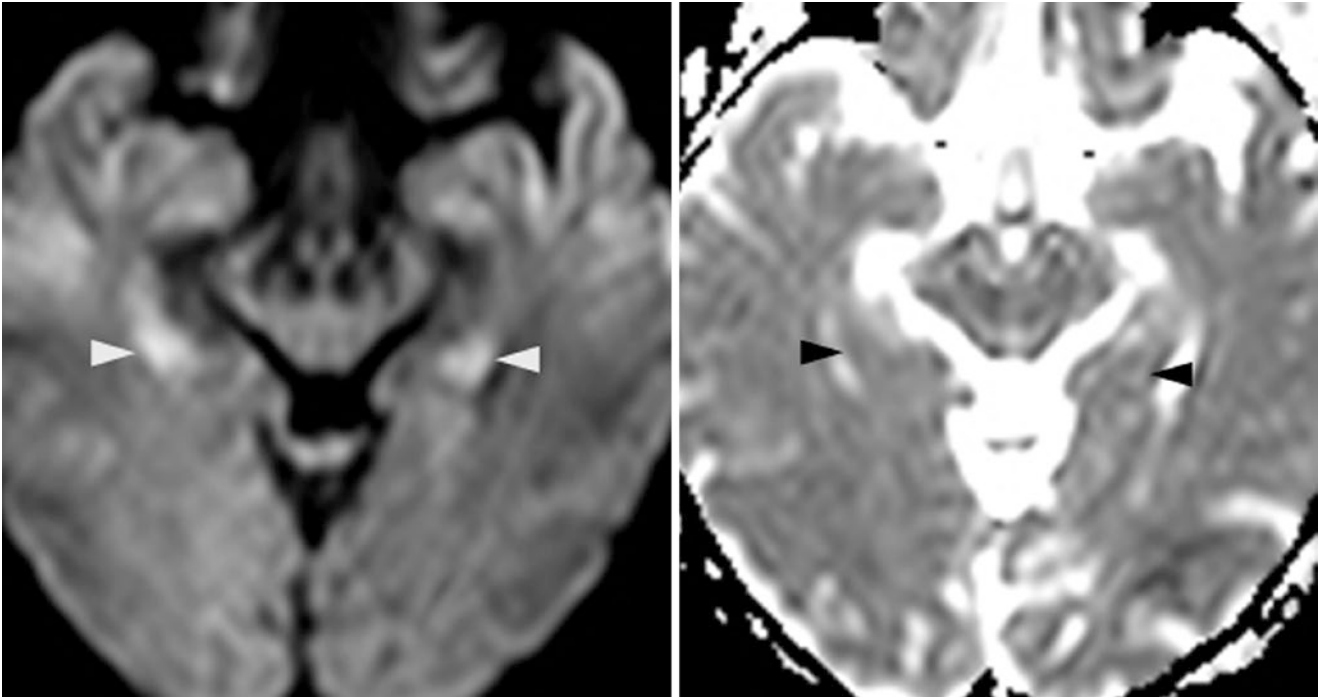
A 53-year-old had a 3 T DWI MRI (*left*) with bright hippocampi posteriorly (*arrowheads*), but corresponding low signal was lacking on the ADC map (*right*)
